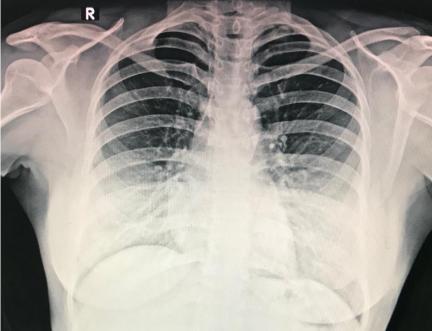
Chest X-rayshowing bilateral opacities in the lower segment.
